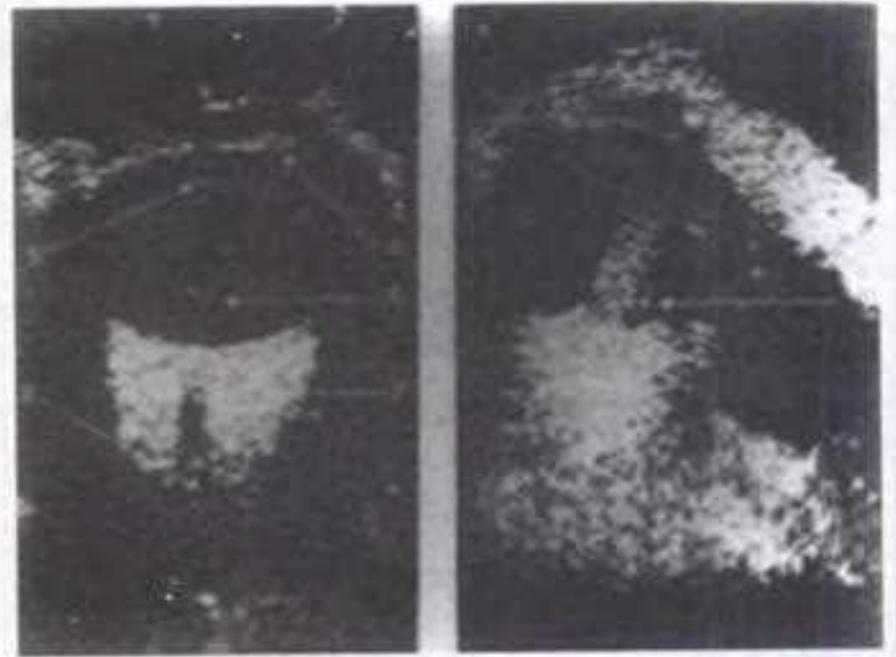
(Left) Linear horizontal B-scan through normal eye and orbit, showing partial outline of globe. Areas shown include: 1, anterior corneal surface; 2, posterior corneal surface; 3, pupil; 4, iris; 5, posterior lens surface; 6, vitreous; 7, orbital fat; and 8, optic nerve. (Right) Ultrasonic scan of malignant melanoma of the choroid (arrowed) (Trevor-Roper and Curran).
